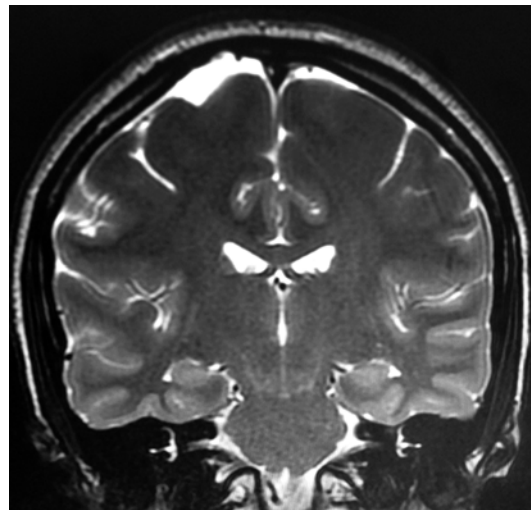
Coronal T2-weighted MR exam revealing the bilateral hippocampal formations
